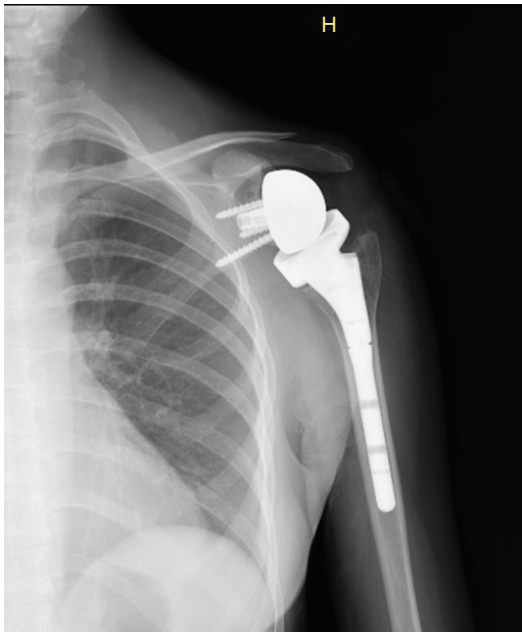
There was no scaffold lysis or implant loosening on radiographs at 9-month follow-up.
